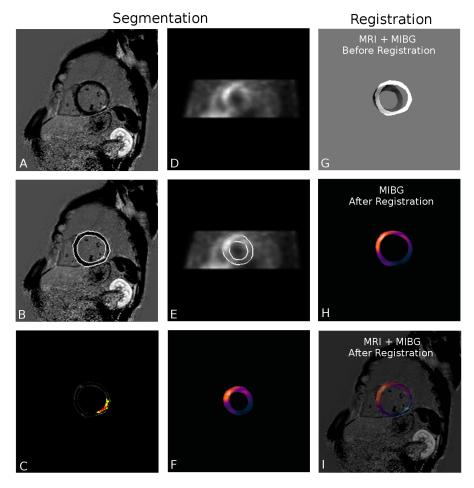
Results of segmentation and registration of MRI and SPECT-MIBG images.
